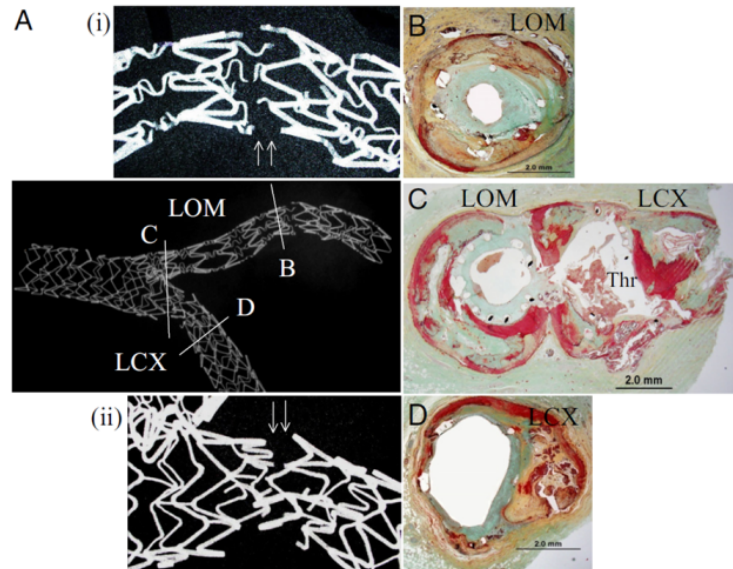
A Case of Grade V Cypher and Taxus Stent Fracture. At 172 days following implantation the patient died from stent thrombosis in the LCX coronary artery. (A) Radiograph of the stented left circumflex and left obtuse marginal (LOM) artery. Note, presence of grade V Cypher stent fracture highlighted in magnified image (i) and another grade V fracture at the bifurcation site in the Taxus stent (ii). (B) Cypher stent in LOM with grade V fracture was associated with restenosis. (C) Taxus stent fracture in LCX was located in the area close to the bifurcation site where the thrombus was located (Thr). (D) The stented LCX segment distal to the fracture was widely patent. Reprinted with permission from Nakazawa et al. [156].
